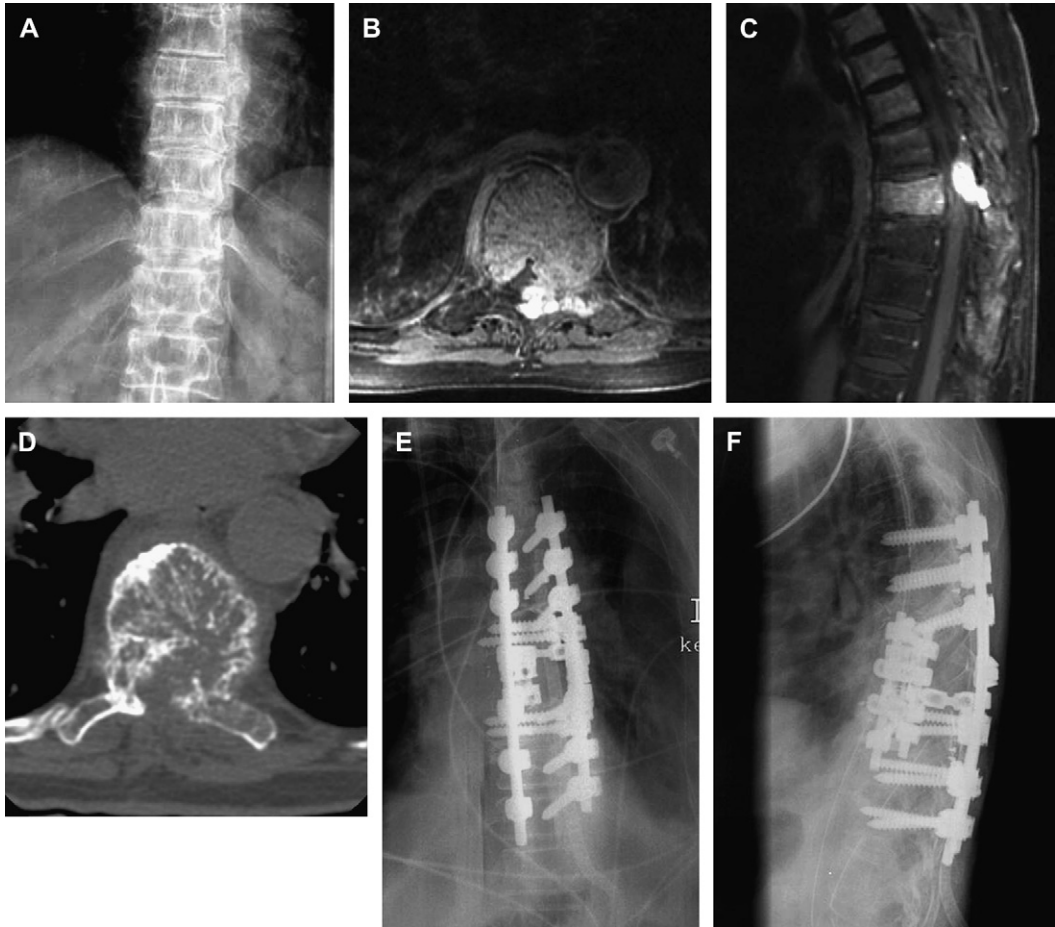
Sixty-eight-year-old female presenting with left leg weakness and pain due to a T8 vertebral hemangioma status after T7–T8 laminectomy. (A) Plain anteroposterior radiograph demonstrates loss of height at T8. Axial (B) and sagittal (C) thoracic MRI show recurrent stenosis and epidural extension of the lesion. Axial CT (D) demonstrates the classic trabecular thickening (honeycombing) of the affected segment. Postoperative anteroposterior (E) and lateral (F) radiographs indicate adequate positioning of the T8 expandable cage following corpectomy and T7–T9 anterior fusion with T5–T11 posterior fusion.
